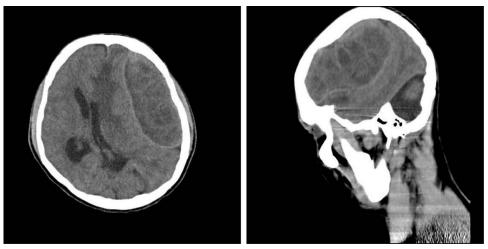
Computed tomography scan of brain—large heterogeneous mass lesion (9.7 × 4.6 × 6.5 cm) in left fronto-parietal lobes with hyperdense rim and internal septae, causing compression of adjacent brain. parenchyma, sulci, and gyri; effacement of left lateral ventricle; compensatory dilatation of right. lateral ventricle; significant sub-falcine herniation (1.8 cm); and bilateral cerebellar hemispheric hypoplasia.
